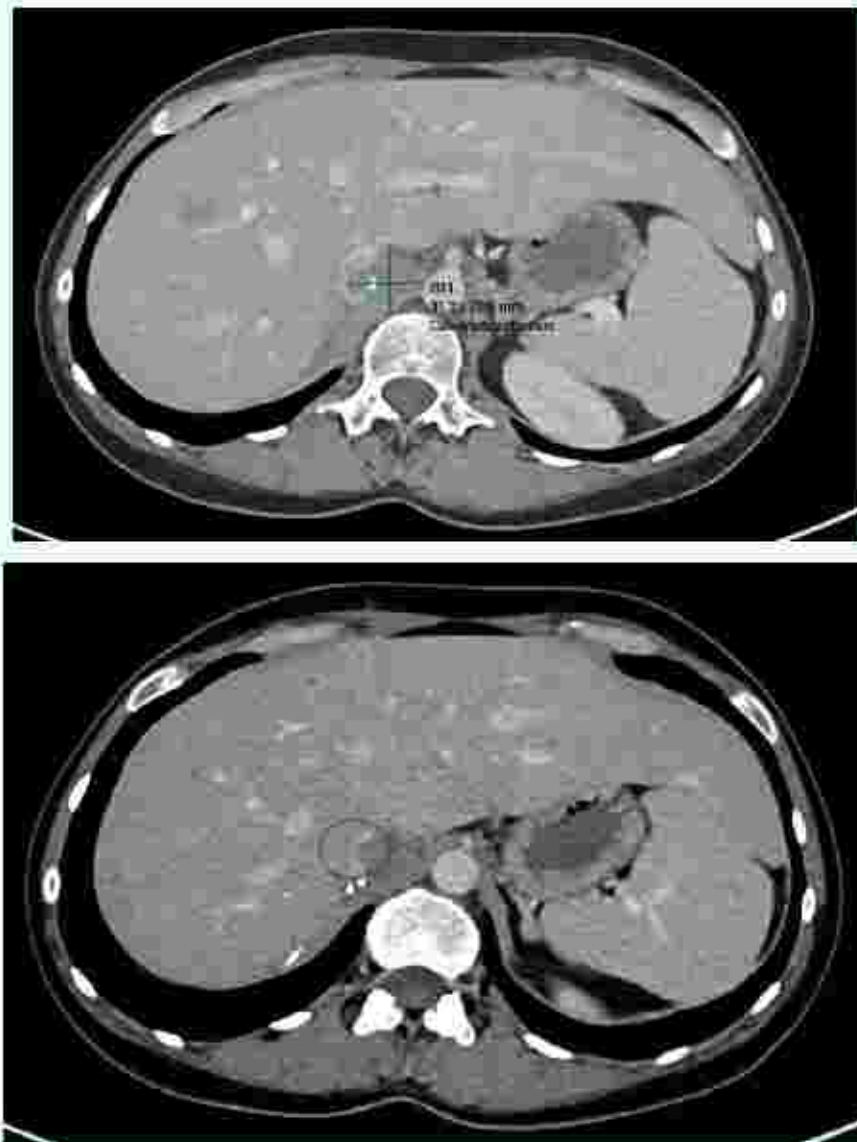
A. CT scan with contrast injection showed right adrenal gland is surgically-absent. Soft tissue mass in the surgical bed measures (3.1cm x 2.9 cm). B. This mass results in complete
